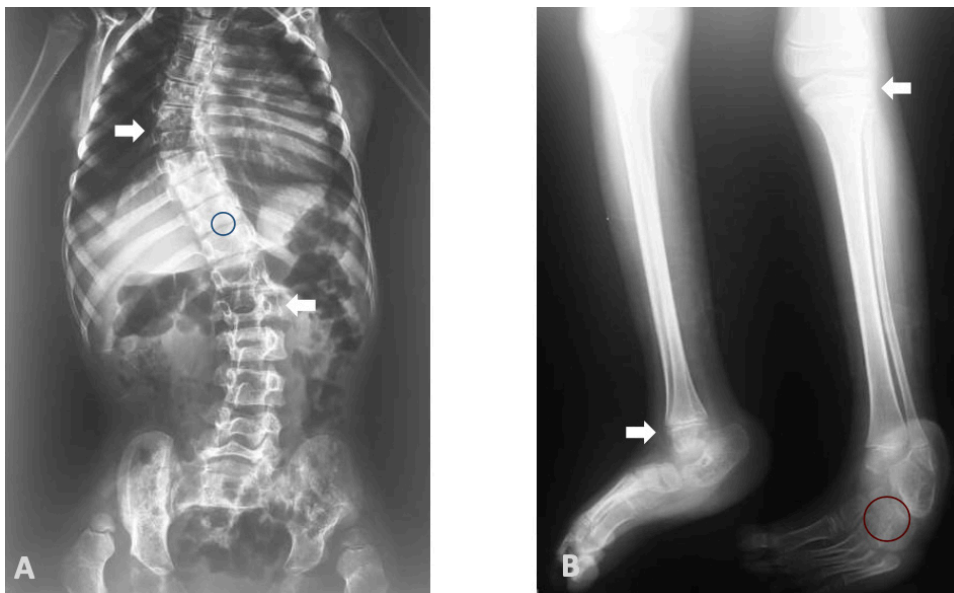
Radiographs of the spine and lower limbs of Brother B (younger sibling) showing dorsolumbar scoliosis with spondyloepiphyseal dysplasia.
